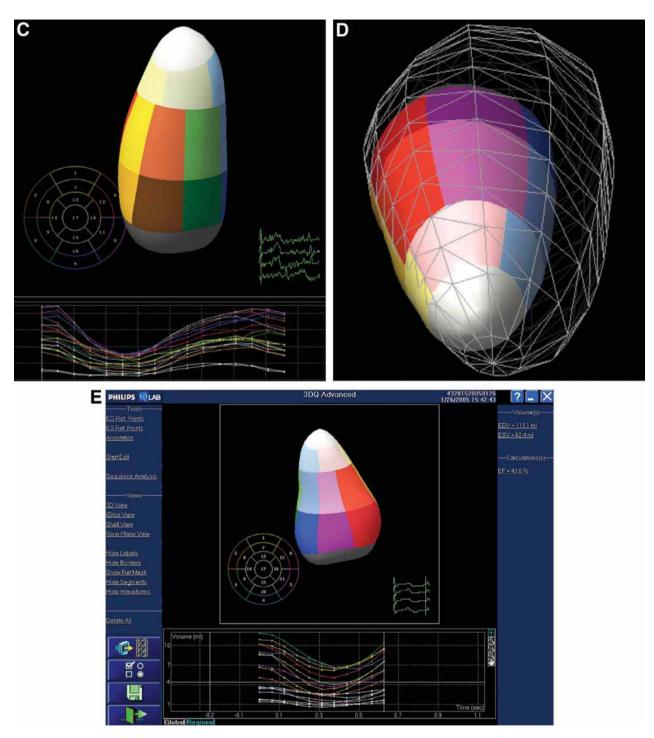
Left ventricle (LV) quantification by three-dimensional (3D) echo. (A) Apical full-volume cropped 3D image. (B) Semi-automatic border detection with multiplanar reconstruction (MPR) in 3D echocardiography. (C) A 17-segment 3D volumetric data for left ventricular segmental analysis. 3D echocardiography overcomes several limitations of 2D echocardiography in quantification of systolic function including: endocardial border definition, foreshortening, off-axis views, and translational motion. It is slated to supercede 2D echocardiography in the assessment of LV function, mass, and volumetric assessments. 3D echo is especially valuable in right ventricular assessment and quantification, with utility comparable to that of cardiac magnetic resonance imaging. (D) LV systolic frame with diastolic reference mesh. (E) Systolic frame in patient with cardiomyopathy and asynchrony. (Please *see* companion DVD for corresponding video.)
